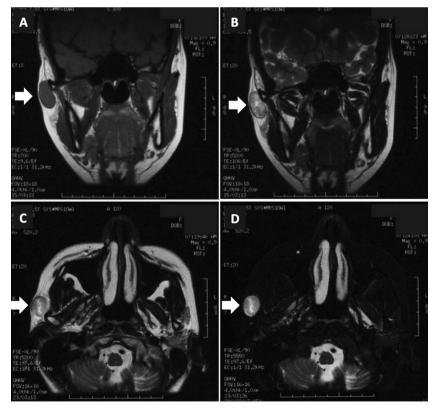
Coronal and transverse magnetic resonance imaging prior to surgery.  $(A, C)T_1$ -weighted imaging, and  $(B, D)T_2$ -weighted imaging tumorous lesion with a non-uniform internal shape, clear boundaries, low signal intensity on  $T_1$ -weighted imaging, high signal intensity on  $T_2$ -weighted imaging and high signal intensity on fat-suppressed  $T_2$ -weighted imaging.
